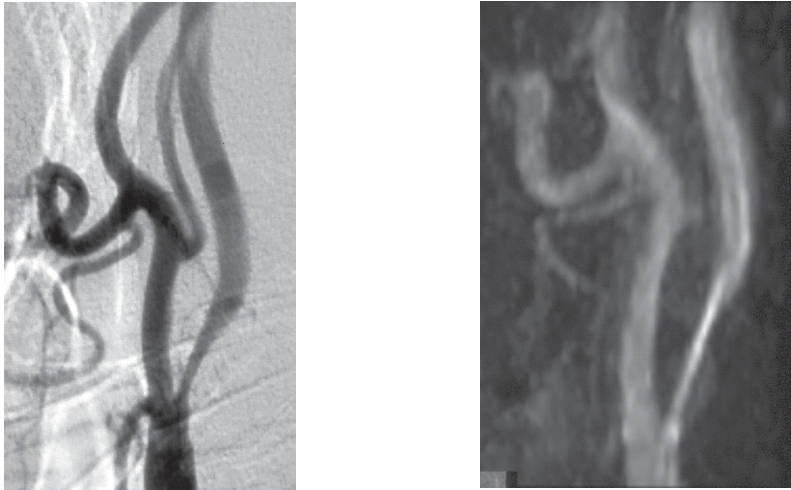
Male (age 64): Digital subtraction angiography on the left (DSA) and time-of-flight magnetic resonance angiography on the right (MRA) both show a moderate stenosis (50-69%) in the internal carotid artery (ICA). The peak systolic velocity (PSV) at Duplex ultrasound (DUS) examination was 250 cm/sec.
